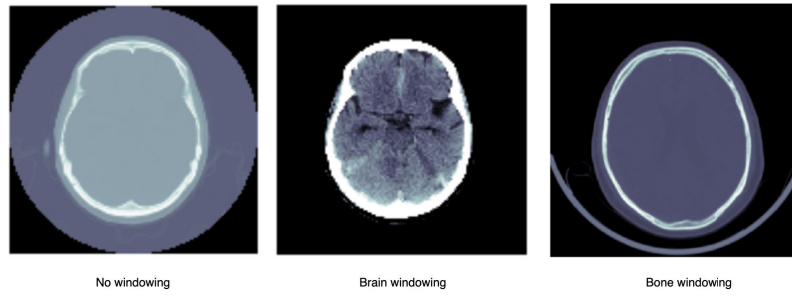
CT scan at different windowing.
